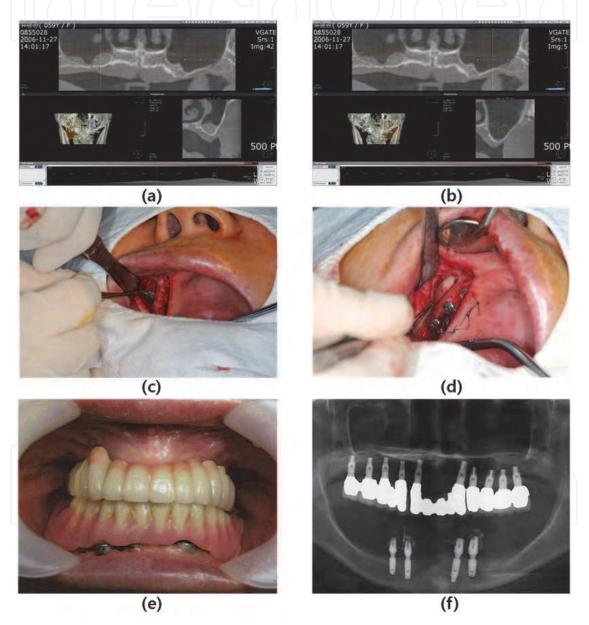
Sinus graft and dental implant treatment with fixed type bridges. Preoperative CT showed severe pneumatisation and alveolar bone loss leaving only thin cortex of 2 mm thickness or less on both sides of the floor of the maxillary sinus (a and b). Sinus graft utilising outfracture osteotomy technique was done on right maxillary antrum (c and d). The same procedure was repeated on the contralateral sides later. Clinical photograph (e) and panoramic radiograph (f) of final prosthesis showed good function without any complication.
